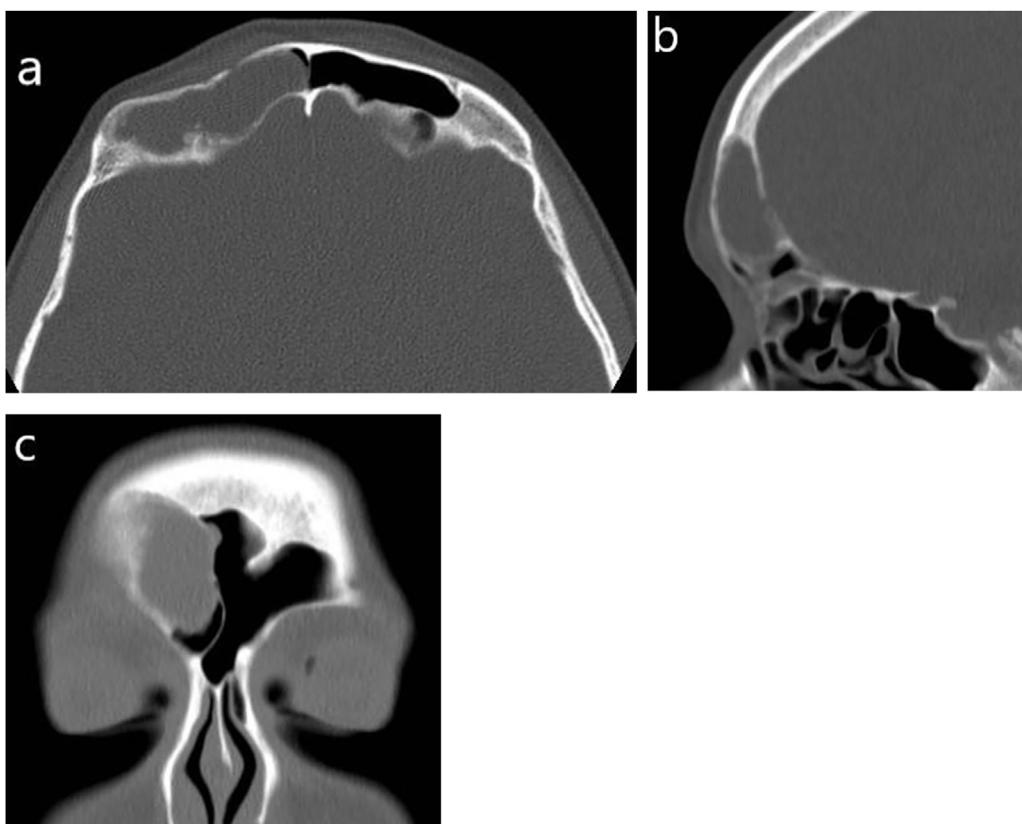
Computed tomography of paranasal sinuses in bone algorithm in axial (a), sagittal (b) and coronal(c) planes. Right frontal sinus lesion with depressed fracture of anterior wall and resorption of the lateral and posterior walls.
